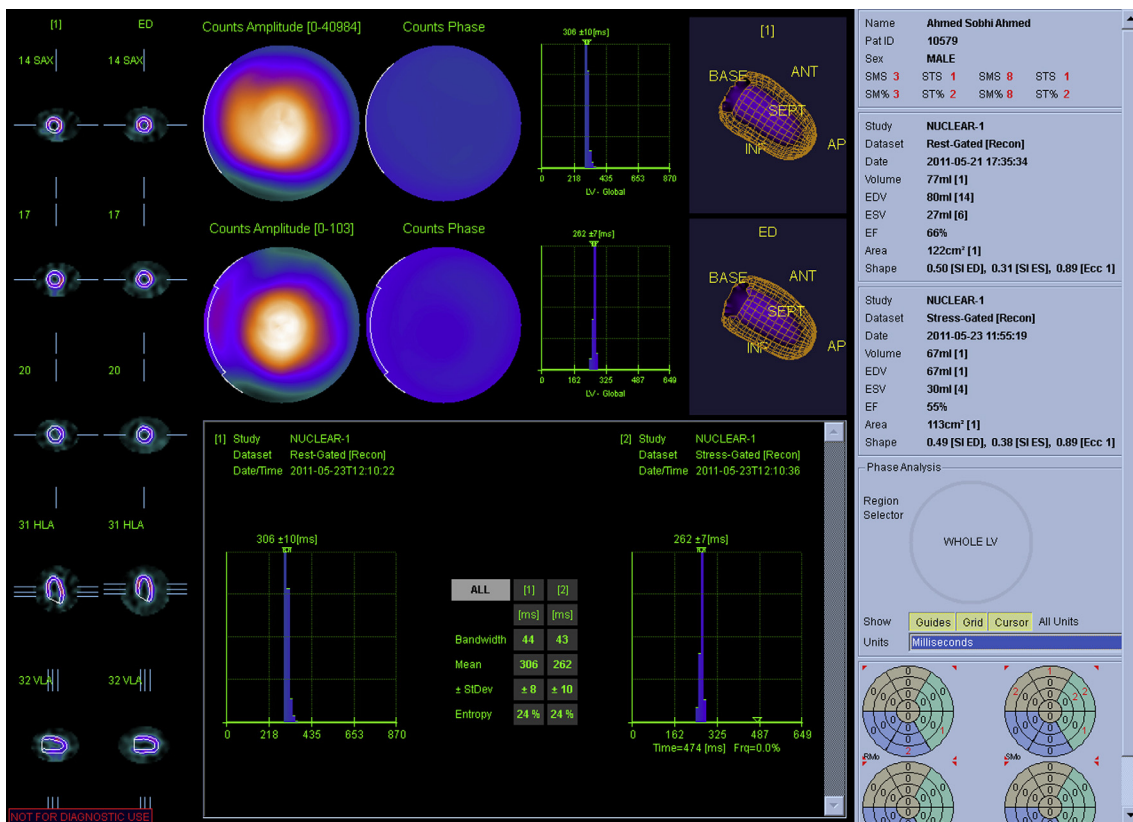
The gated SPECT study of the control case. The left ventricle ejection fraction is preserved with left ventricle ejection fraction (LVEF) of 55% and there is uniformity in the LV histogram distribution with bandwidth of 44°, standard deviation of ± 8° and Entropy of 24%. These values represent synchronous left ventricular contraction.
